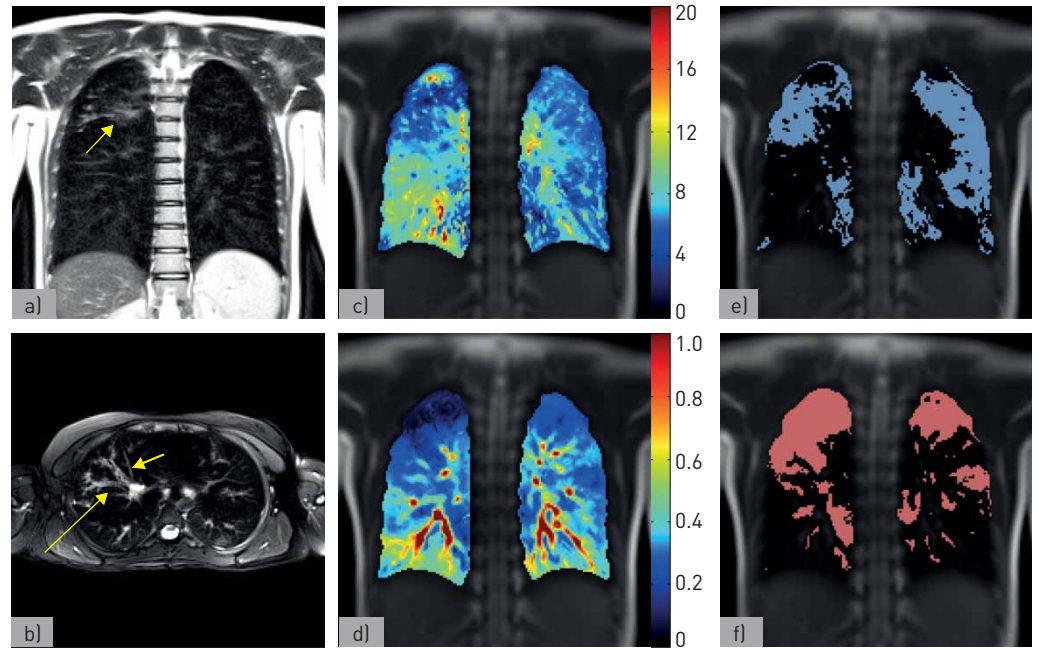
Example of a child with advanced lung disease: a 12-year-old girl with cystic fibrosis. a) Coronal HASTE (half-Fourier acquisition single-shot turbo spin-echo) sequence shows mild bronchiectasis and peribronchial infiltrates in the right upper lobe (arrow) (Eichinger Score 10 (R1)). b) Axial T2-weighted BLADE sequence shows moderate bronchial wall thickening in the right upper lobe (short arrow) and mucus plugging in the right upper lobe (long arrow). c, d) Functional magnetic resonance imaging shows c) large regions with reduced fractional ventilation, which are spatially matched with d) areas of decreased relative perfusion. e, f) Masks overlaid on morphological images present e) fractional ventilation defects (36% of the slice area) and f) relative perfusion defects (31% of the slice area). Both lung clearance index (13.4 lung turnovers) and forced expiratory volume in 1 s [ $-3.1$  z-scores] showed pathological values.
